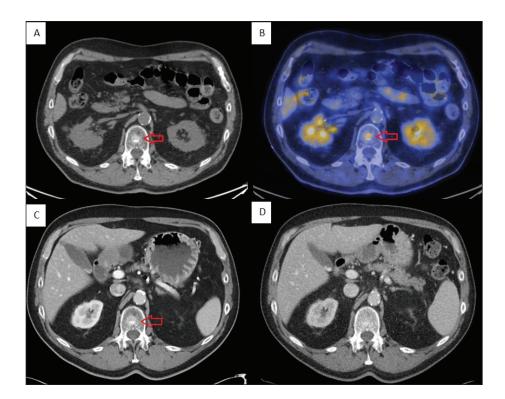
Imaging prior to palliative FOLFOX-6 chemotherapy demonstrates a metastatic lesion in L1 on computed tomography (CT) without contrast (A) and the same image enhanced with positron emission tomography (B). Contrast CT demonstrates no interval change inL1 lesion after 4 cycles of FOLFOX-6 (C) but significant regression of L1 lesion after 8 cycles of chemotherapy (D).
